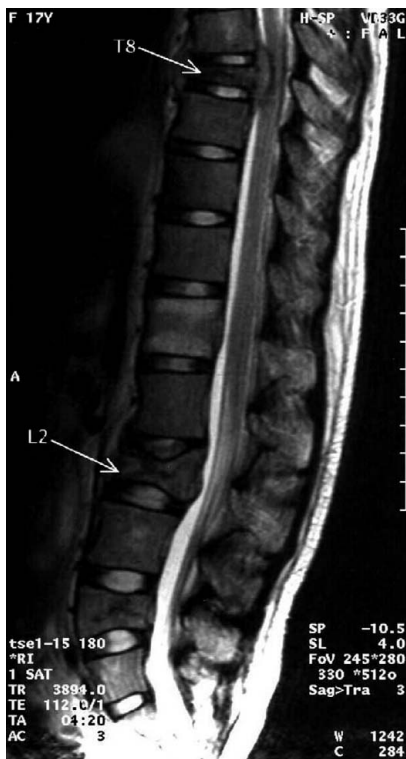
Magnetic resonance imaging of the thoracic spine shows T8, L2 and L4 vertebrae compression fractures with spinal cord involvement.
